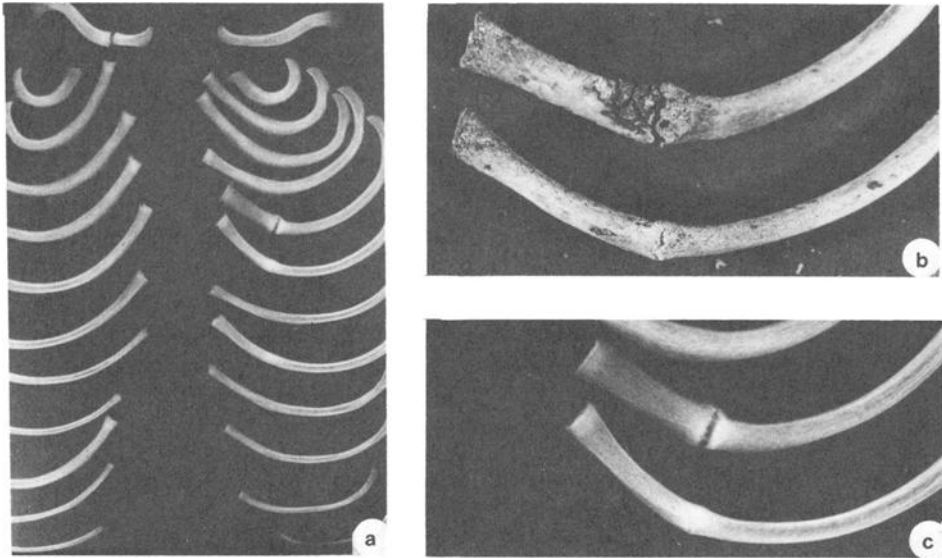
Ribs and clavicles of Body A: (a) general distribution of fractures; (b) reparative callus on two ribs of left rib cage; and (c) radiograph of the ribs shown in (b).
